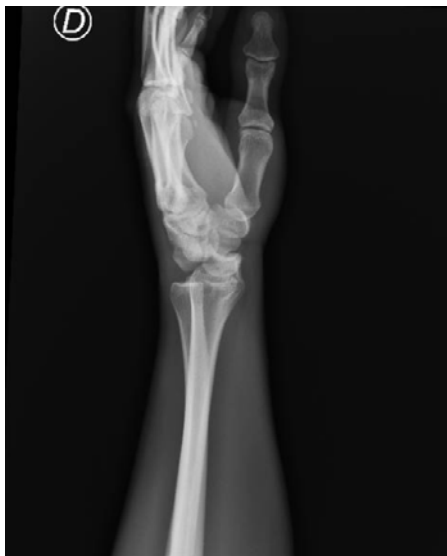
Lateral X-ray of the right wrist after the trauma. A dorsal trans-scaphoid perilunate fracture dislocation is observed.
